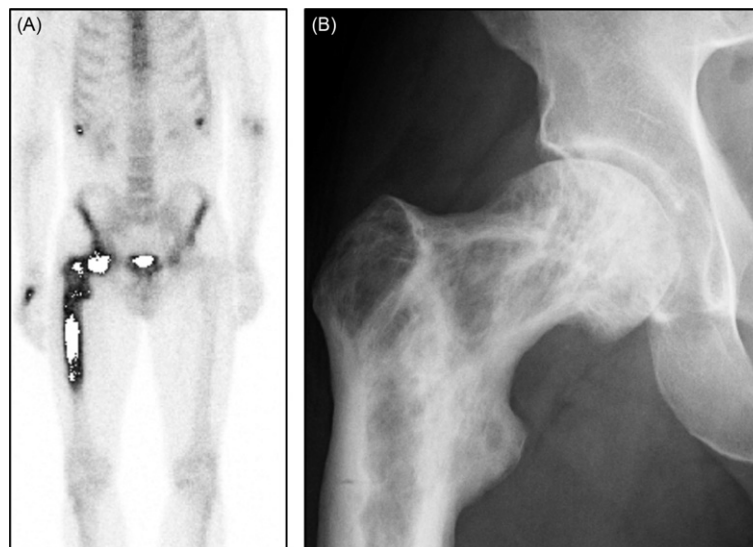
Radiologic and scintigraphic features of Paget's disease. Panel A: Radionuclide bone scan of a patients with Paget's disease affecting the upper right femur. There is intense tracer uptake affecting the upper two-thirds of the femur. Panel B: X-ray of the upper femur from then same patient showing coarsening of trabeculae throughout the upper femur with areas of osteosclerosis alternating with areas of osteolysis. The right femur is enlarged and a pseudofracture is just visible on the lateral aspect of the femoral shaft at the level of the lesser trochanter.
